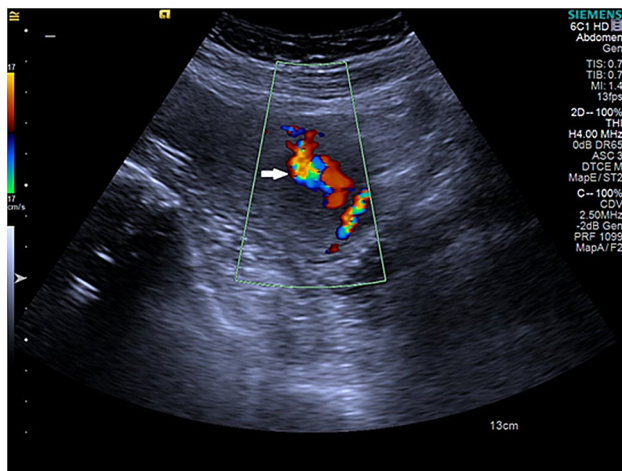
Ultrasound Doppler showing “yin yang” pattern in pseudoaneurysm
